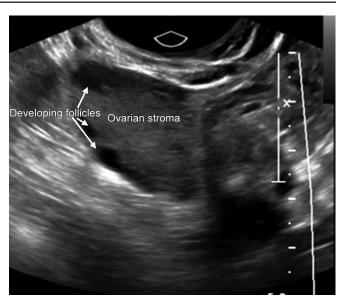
Transvaginal ultrasound of the ovary. Note ovarian stroma and developing follicles
